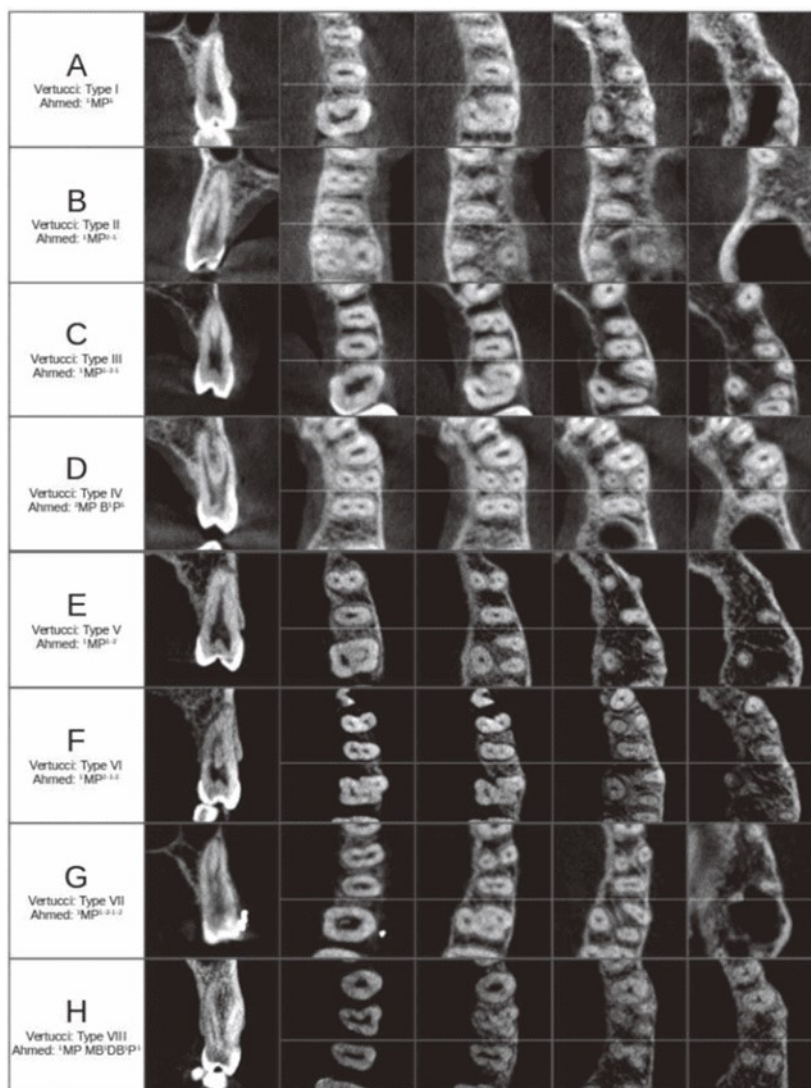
Several common canal configurations are demonstrated using coronal and axial sections of CBCT scans. All Vertucci types are represented, and the corresponding Ahmed et al. classifications are included below.¹³
